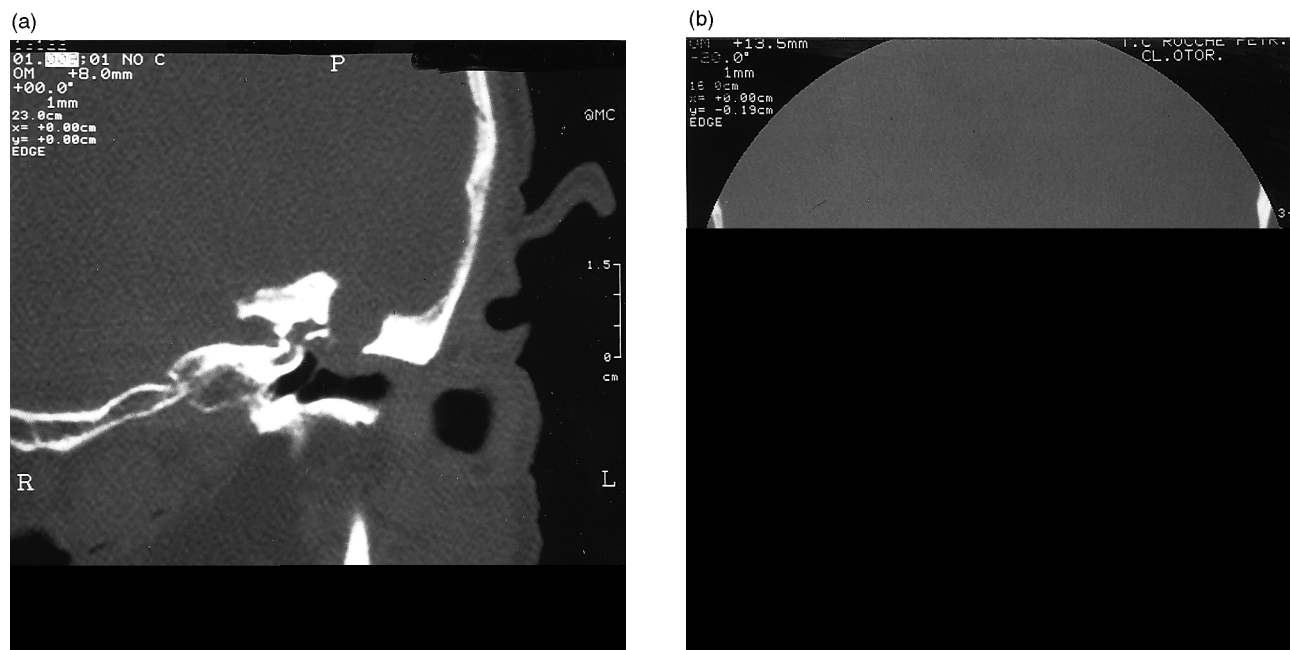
(a) Preoperative CT coronal view of petrous bone cholesteatoma. (b) Postoperative coronal view (transabyrinthine approach).
